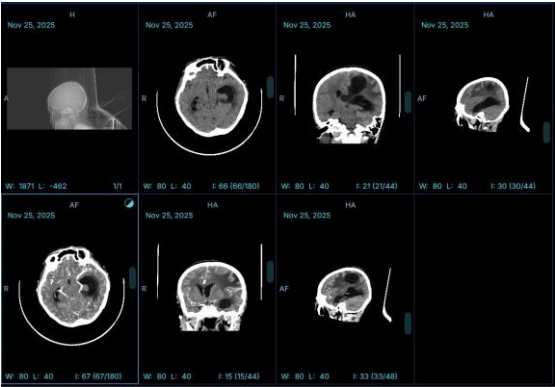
CT scan dated November 25, 2025
